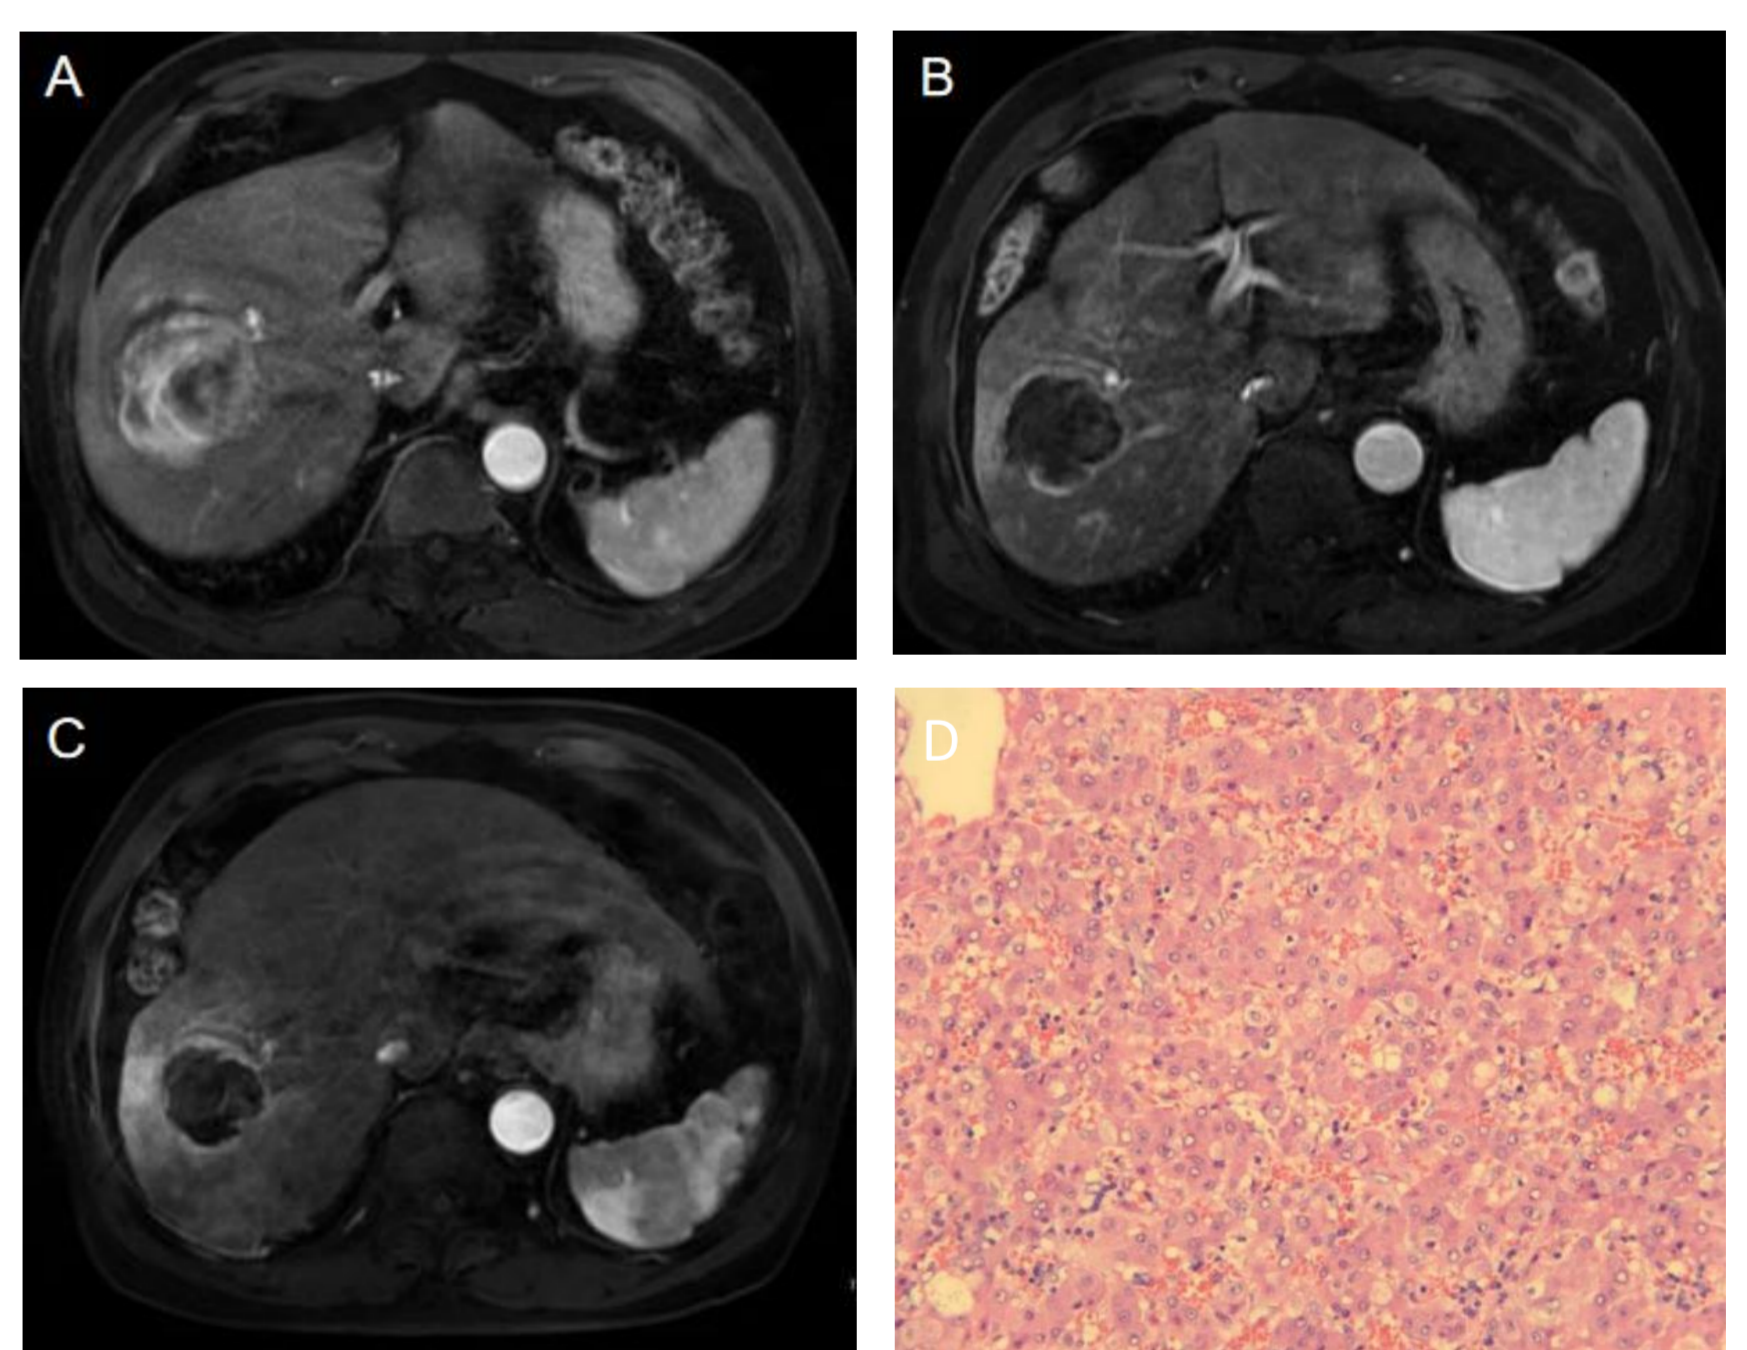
MR imaging of the 67-year-old male. (A) MR scans before A-SIRT (RL). (B) MR scans three months after A-SIRT (RL). (C) MR scans six months after A-SIRT (RL). (D) Postoperative pathology biopsy showed well-differentiated HCC with a tumor necrosis percentage of 70%, consistent with post-treatment changes. The surrounding liver tissue exhibited nodular cirrhosis, hepatocyte atrophy with sinusoidal dilatation and congestion, and mild steatosis.
